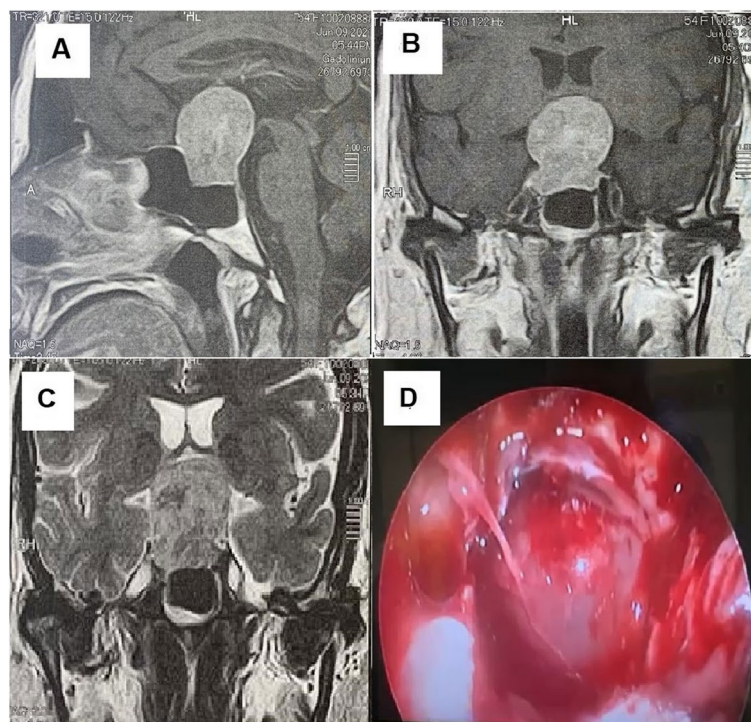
A 30-year-old male patient with an anterior cranial fossa meningioma: A sagittal T1 post-contrast MRI image, B coronal T1 post-contrast MRI image, and C coronal T2 MRI image showing a large sellar lesion with suprasellar extension, an intense enhancement, and hyperintense in T2. D Intraoperative endoscopic view revealing the exposed dura after opening the sellar floor
